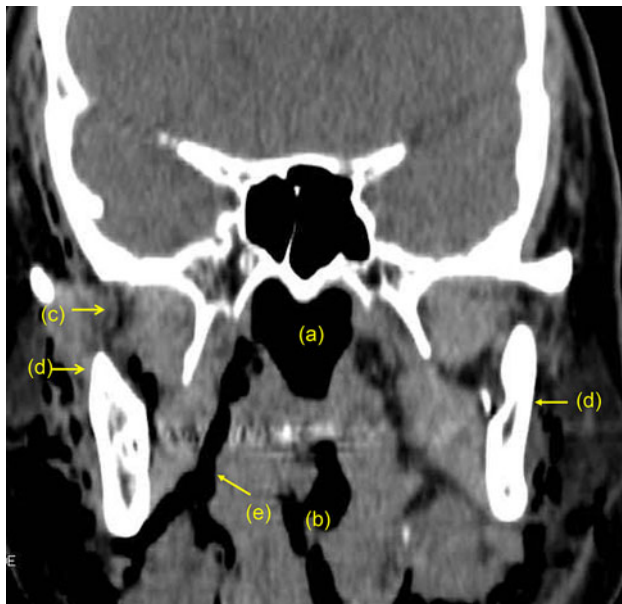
Coronal section of the computed tomography scan demonstrating the false tract of retropharyngeal dissection filled with air. *a* Nasopharynx, *b* oropharynx, *c* infratemporal space, *d* mandible, *e* false tract of the retropharyngeal space
